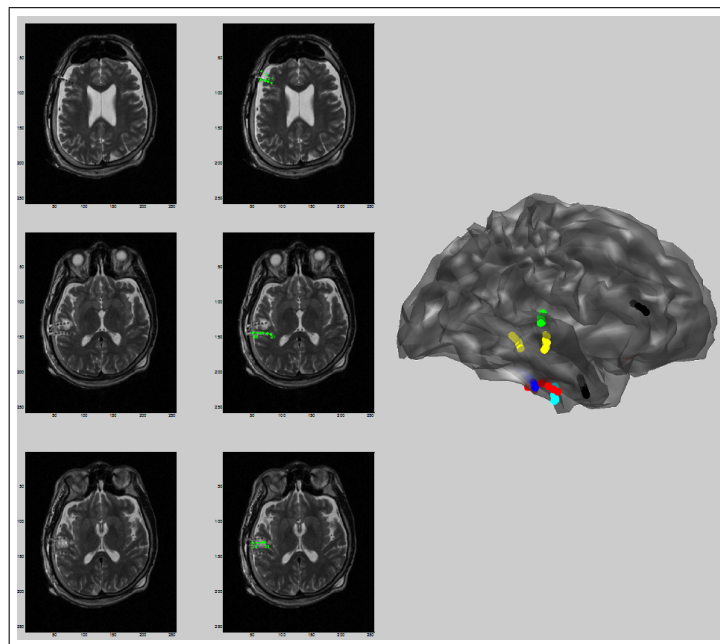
Locations of the deep electrode contacts are shown; i) on the T2 weighted MR images and ii) on the cortical source space.
